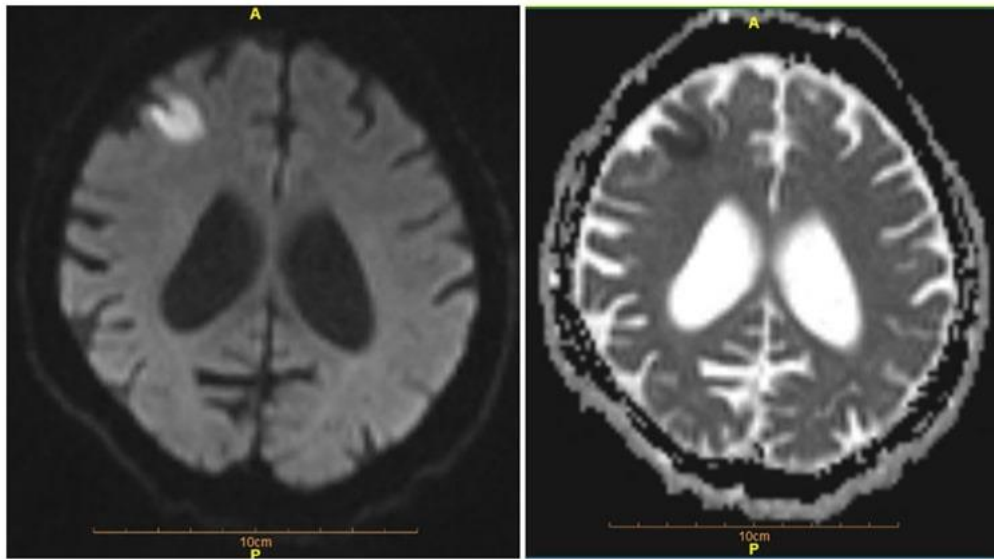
Axial view of a magnetic resonance image of the brain, an increased signal in diffusion-weighted imaging sequence (DWI) (A) and decrease signal in apparent diffusion coefficient (ADC) (B); consistent with Right cortical frontal acute ischemic infarction, which is in the territory of superior division of right middle cerebral artery.
